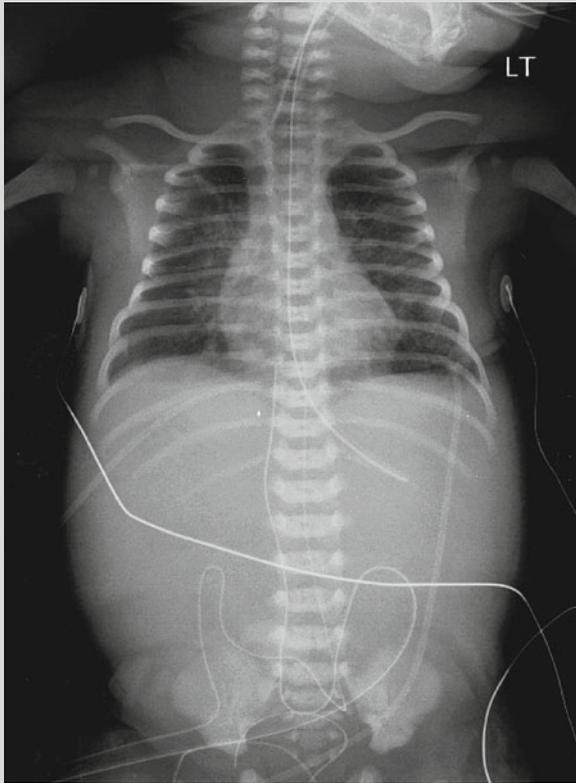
Chest radiograph on admission showing fluffy lung fields, flat diaphragms, no air leaks
